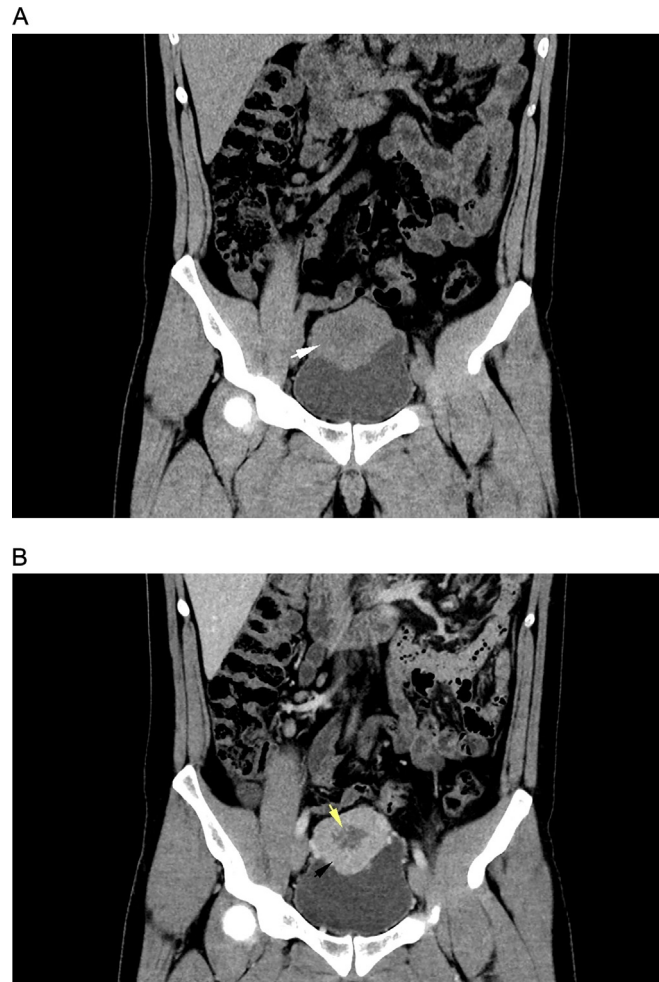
(A) Computed tomography (CT). Coronal section in a soft tissue window showing a mass with soft tissue density (white arrow) dependent on the wall of the bladder dome, endophytic growth, and lobulated contours. (B) Contrast-enhanced computed tomography (CT). Coronal section in a soft tissue window showing avid enhancement of the mass (black arrow) and a necrotic center (yellow arrow).
